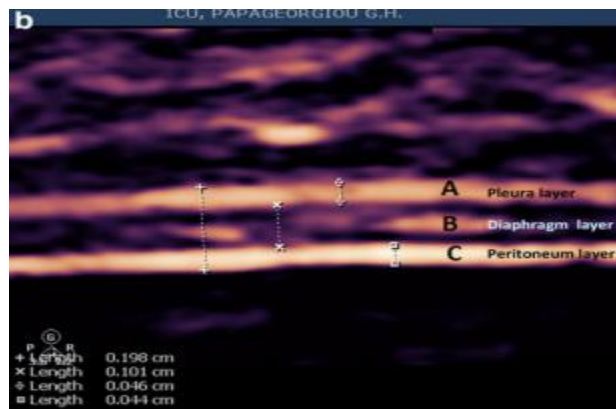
B-mode sonography of the diaphragm in the zone of apposition [39].
